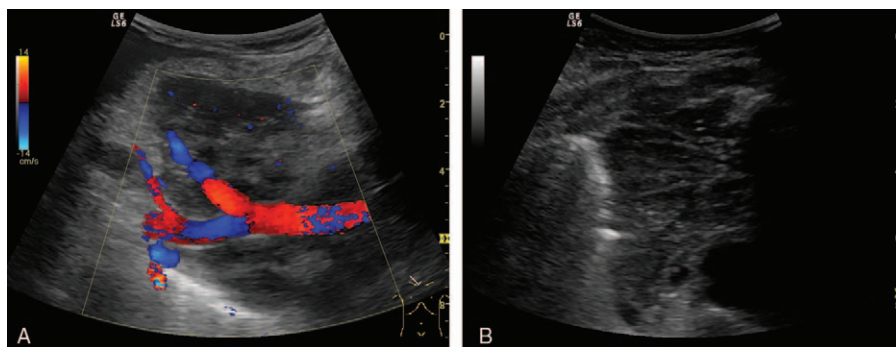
A, Large hypoechoic irregular tumor engulfing brachiocephalic trunk and its branches (color Doppler mode)—right parasternal approach of a large B cell mediastinal lymphoma. B, Hypoechoic irregular shape inhomogeneous tumor, invading the anterior thoracic wall—B cell lymphoma.
